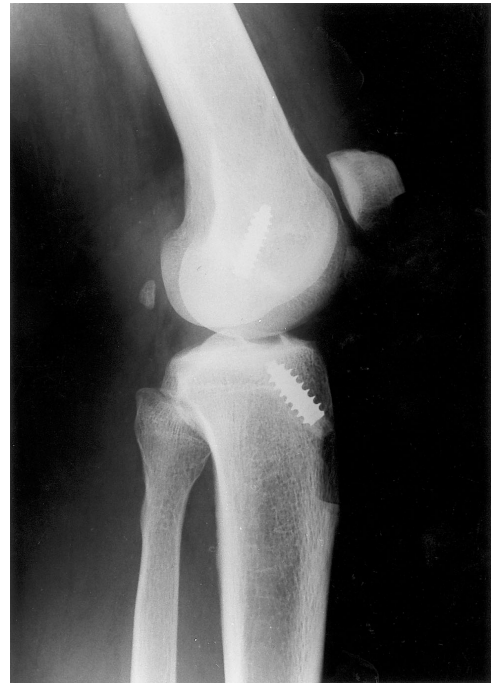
Lateral radiograph of the left knee showing a transverse fracture of the patella.
